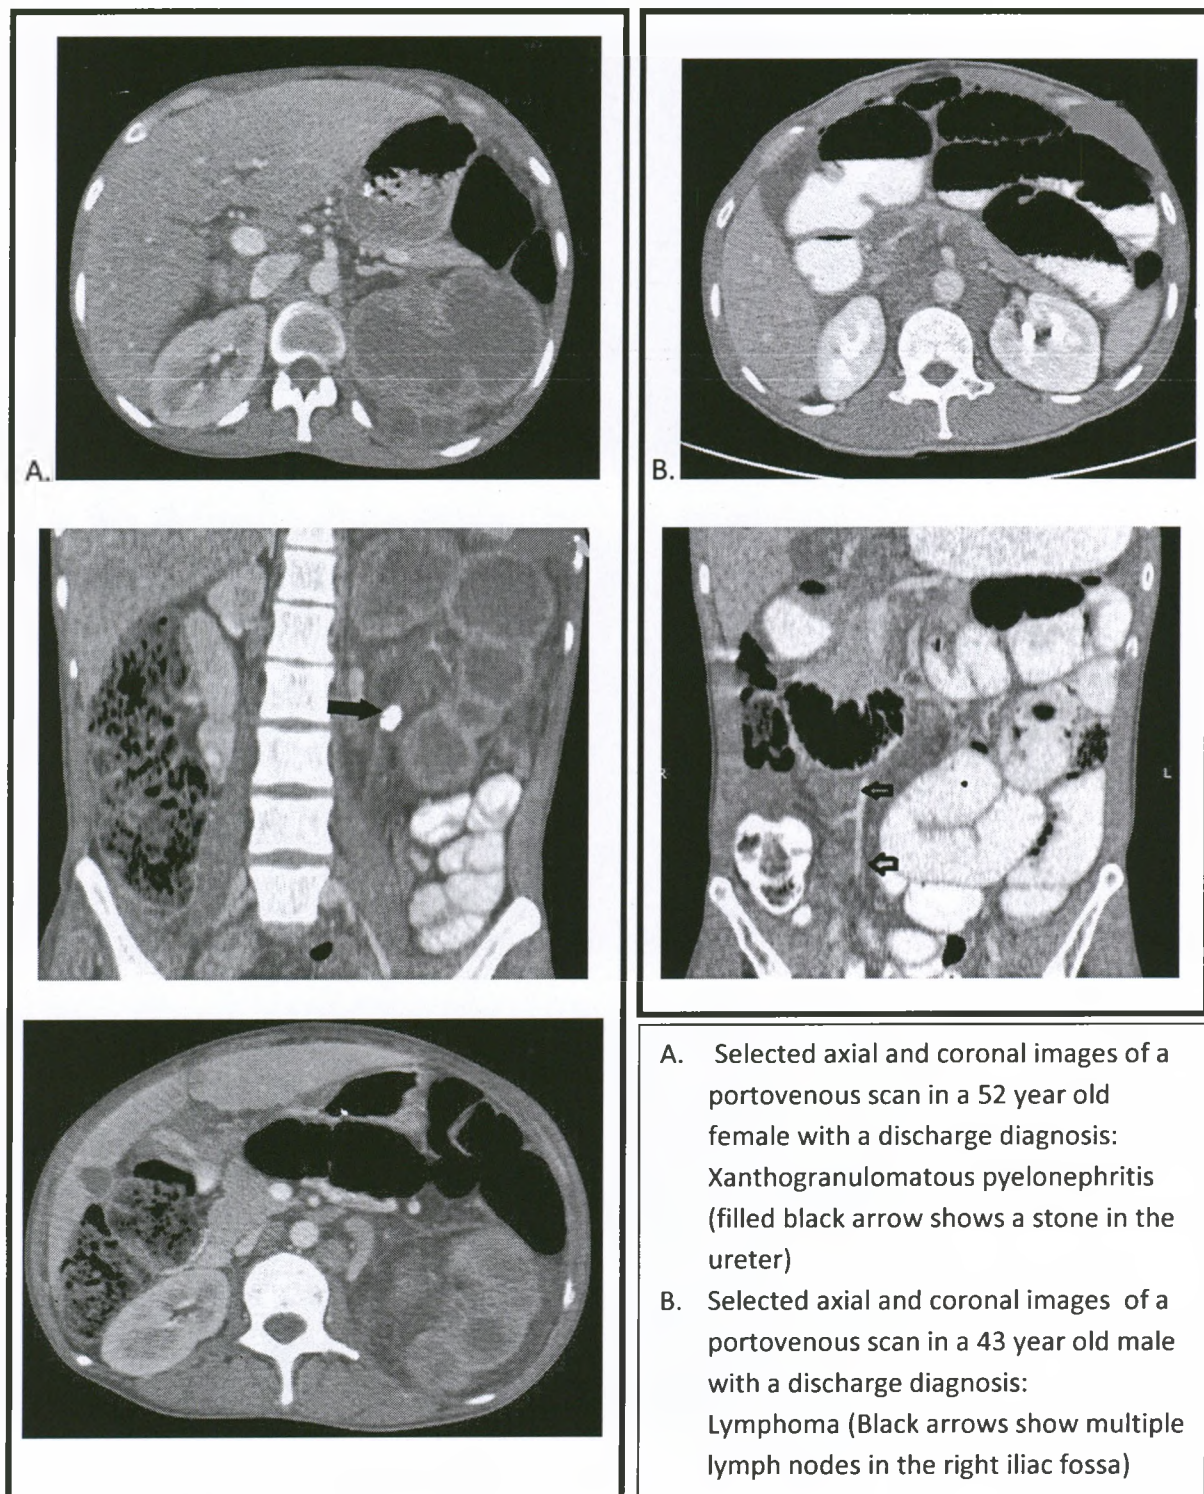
Selected post contrast axial and coronal CT images of two patients that had laparotomy whose CT scan showed features suggestive of abdominal TB but had a different discharge diagnosis
